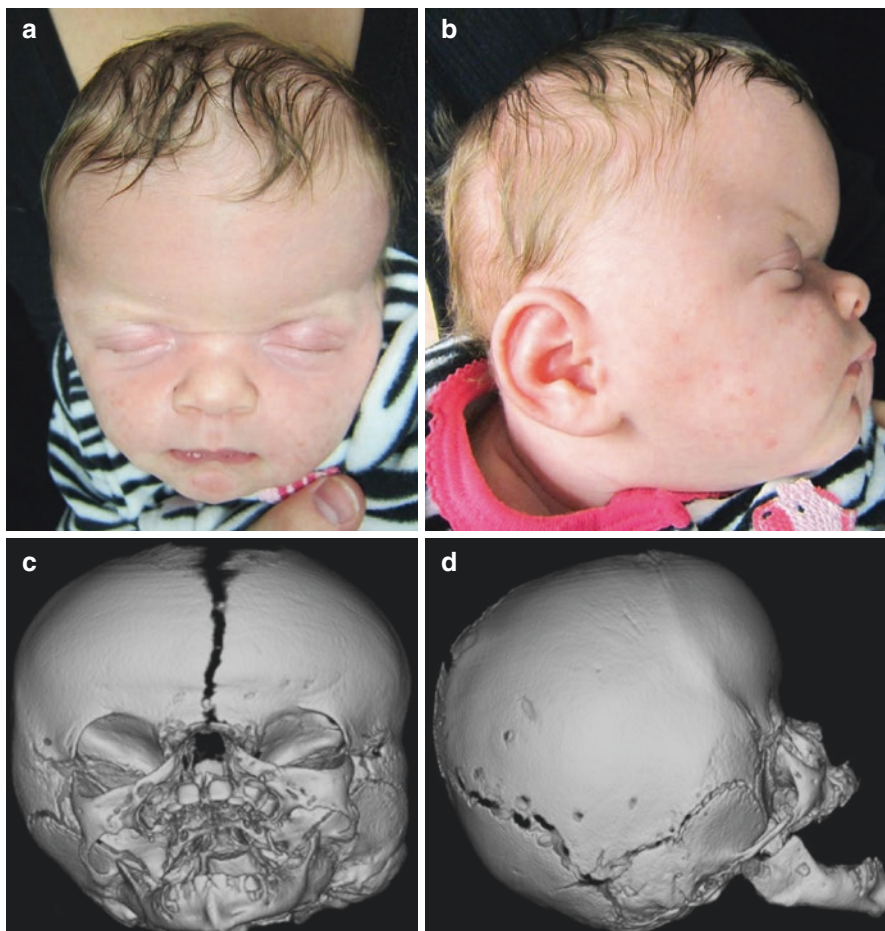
Two-month-old male with Muenke syndrome (a, b). Preoperative CT images (c, d). Patient in consolidation phase of distraction (e, f) and post-distraction device removal CT scan (g, h). One year after posterior vault distraction osteogenesis without additional surgery (i, j)
